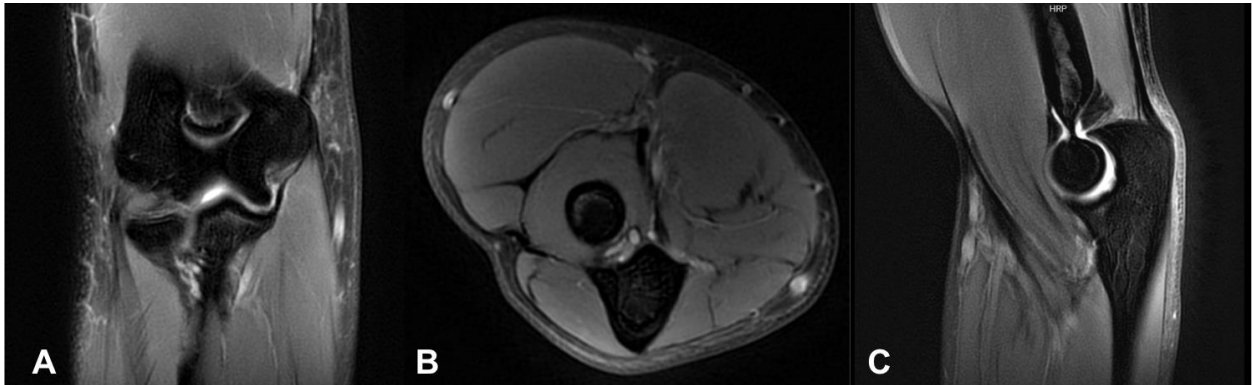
Magnetic resonance imaging of right elbow. Fat-suppressed (FS) magnetic resonance imaging (MRI) of the right (R) elbow. A, Coronal section of R elbow demonstrating anterior mass of inflamed synovial tissue within the radiohumeral joint with the ulnar collateral ligament intact. B, Axial section of R elbow demonstrating fluid or inflammatory infiltrate between the olecranon and humerus. C, Sagittal view demonstrating dark, thickening of the synovial capsule superior to the tip of the olecranon.
